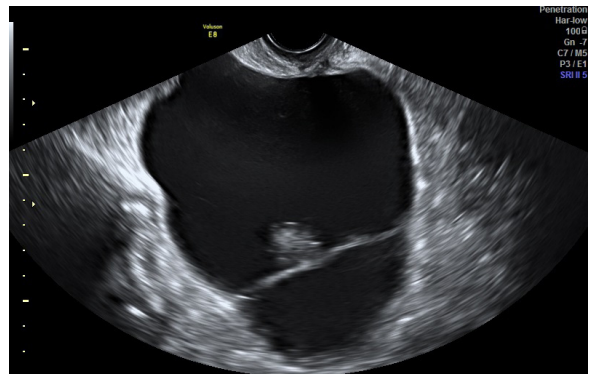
Transvaginal ultrasound image of a multilocular–solid Brenner tumor. There is a septum in the anechoic cystic component. The internal cyst walls are regular with some calcifications foci in the wall
